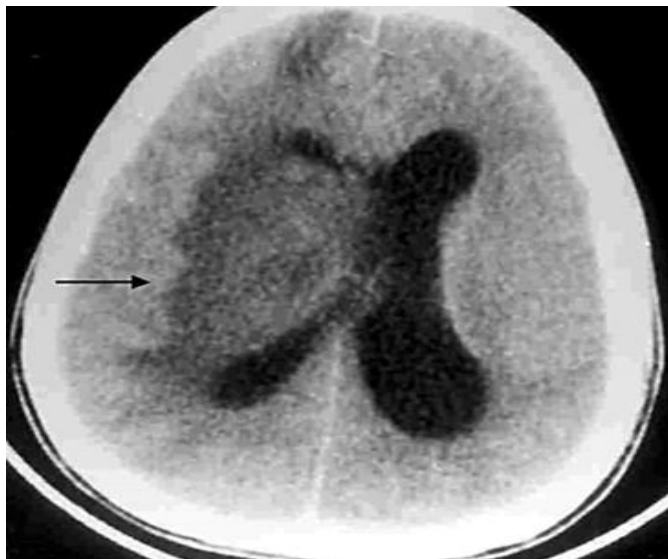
CT PNS and brain axial section showing hypodense area (arrow) in left thalamus and frontal region - suggestive of intracranial extension in early stages of abscess.
